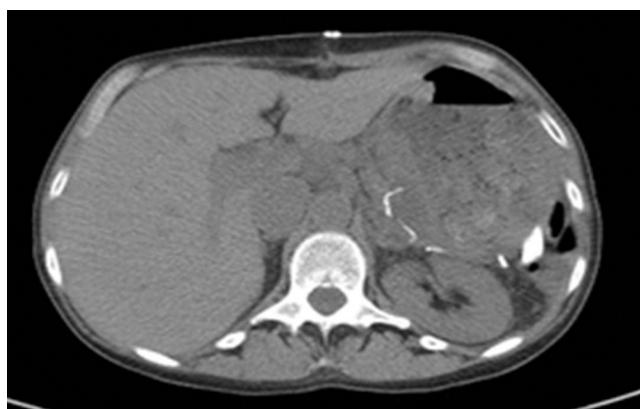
Post operative CT of abdomen and pelvis showing post surgical changes with distal pancreatectomy and splenectomy and with fluid collection around the pancreas.
